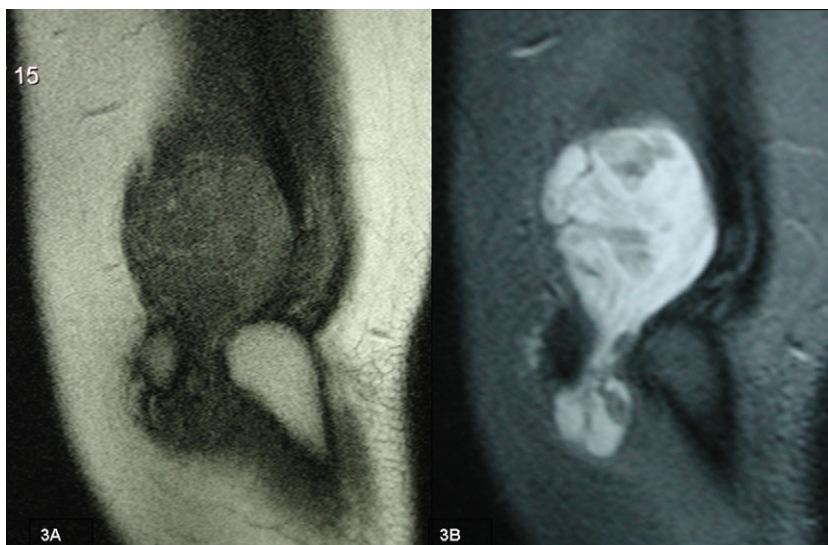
MRI showing an hourglass lobulated soft tissue mass in the posteromedial aspect of the elbow seen on T1 (A) and T2 (B) weighted and fat suppressed sagittal images.
